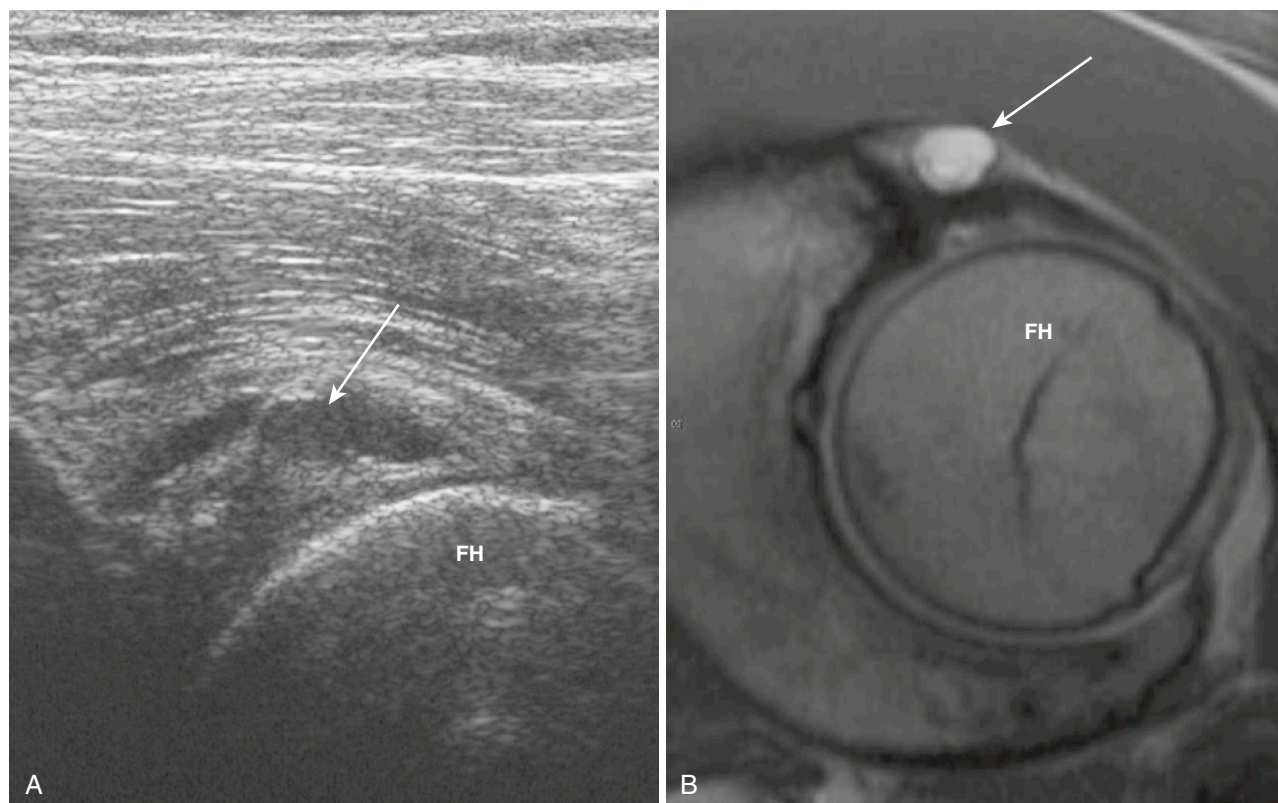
Hip labral tear. A, Ultrasound shows a hypoechoic mass (arrow) arising from the triangular labrum. B, MRI arthrogram.
